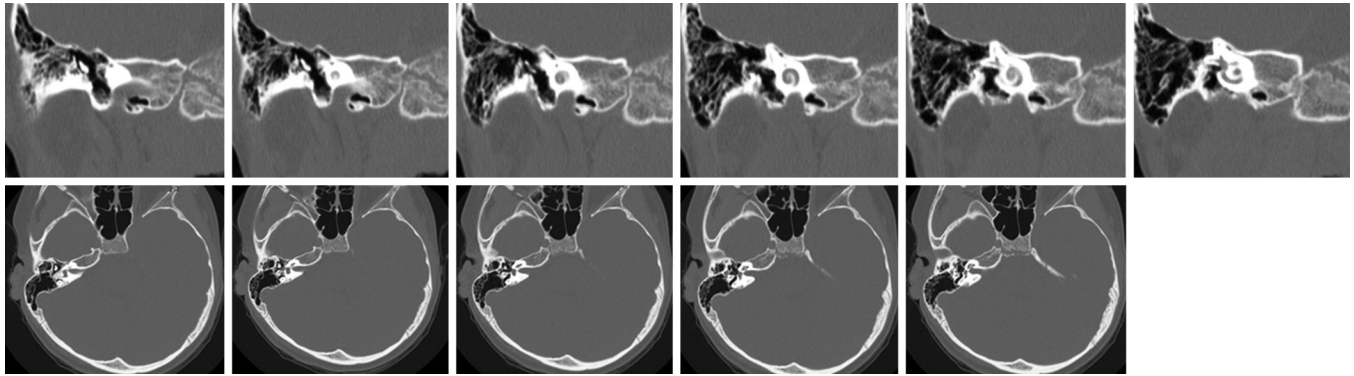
Series of coronal and axial high-resolution CT scans of the temporal bone. Good candidate for atresiaplasty. On coronal imaging, note good height of tegmen, well-aerated middle ear and mastoid, fused malleus–incus, incudostapedial joint intact, stapes better seen on axial sections, oval window open, good distance between malleus–incus complex and atretic plate. On axial imaging, incudostapedial joint nicely imaged, stapes present, oval window open, fused malleus–incus, well-aerated mastoid and middle ear.
